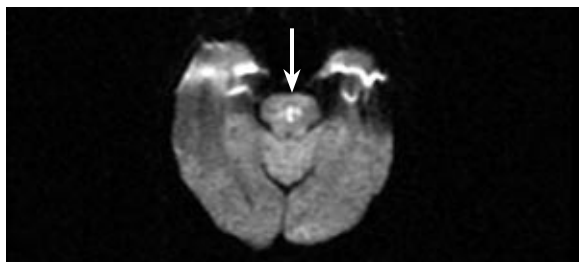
Axial diffusion-weighted MR image shows hyperintense signal within the central and bilateral paramedian pons.
